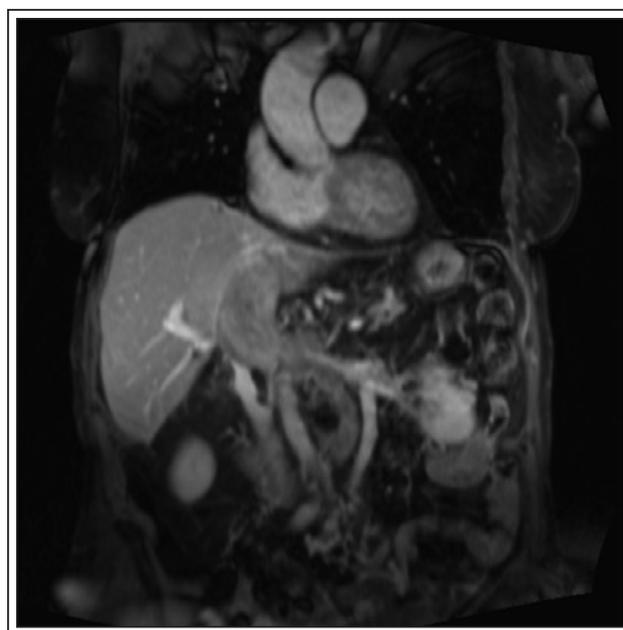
Sagittal MRI demonstrating inferior vena cava thrombus to the level of hepatic confluence.
